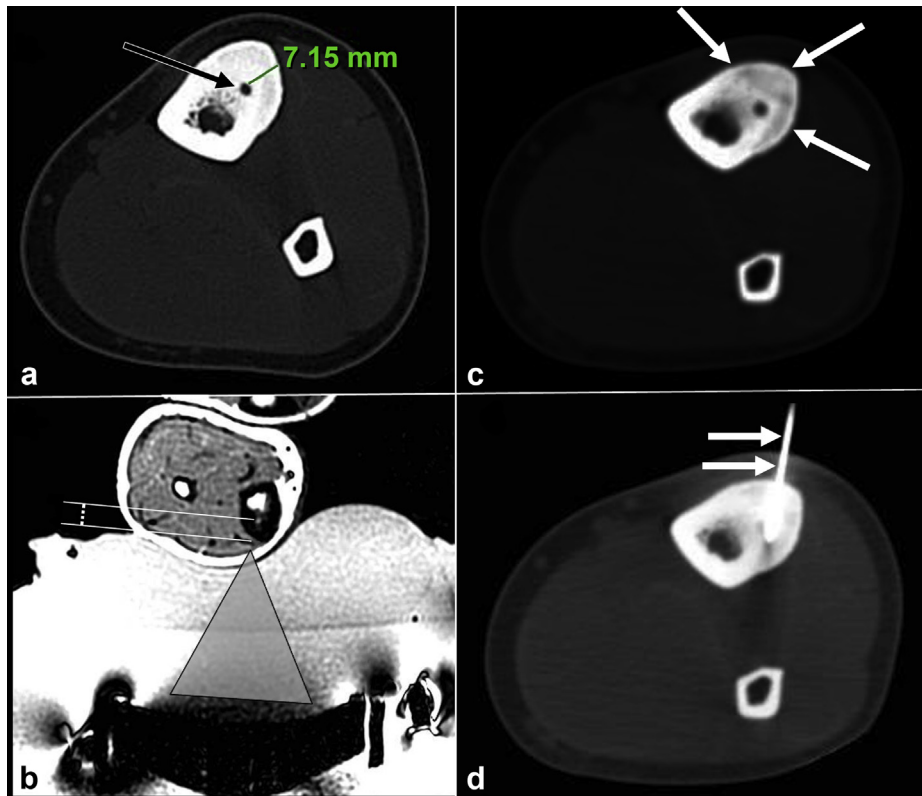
Osteoid osteoma of the tibia. (a) Axial CT image of the lesion (black arrow). Note the thickness of the surrounding bone reaction (7.15 mm). (b) Intraprocedural image during MRgFUS treatment. The gray triangle represents the US beam, the parallel line calipers represent the bone thickness needed to penetrate to treat the nidus. (c) Axial CT image after treatment showed the "ring," the interface between ablated and non-ablated bone tissue. Note that the nidus is not within the ablated area. (d) Axial CT image of subsequent RF ablation treatment with the probe (arrows) within the nidus.
